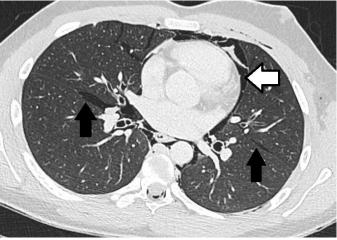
16 year old male with pneumomediastinum Technique: Contrast enhanced CT. Axial view through the mid thorax in lung windows.
